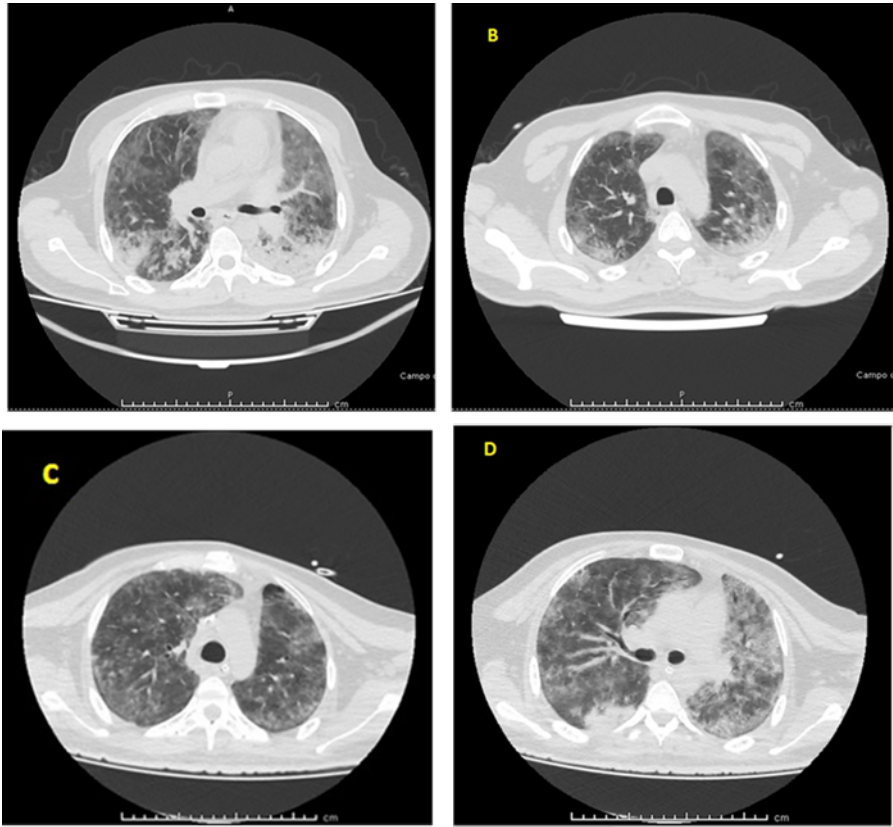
Computed Tomography of the Chest
